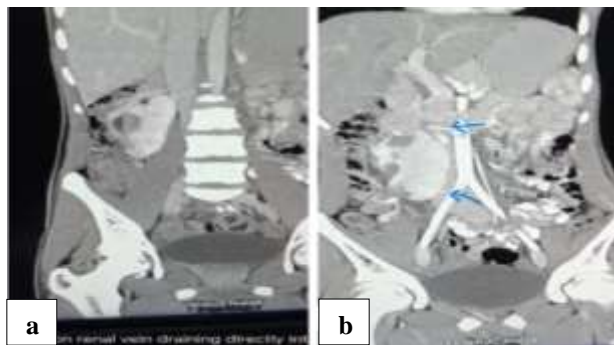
(a) Coronal view of venous phase in contrast CT scan showing single renal vein draining both kidneys, and (b) coronal view of arterial phase of contrast CT scan showing two renal arteries arising from aorta and common iliac artery.
